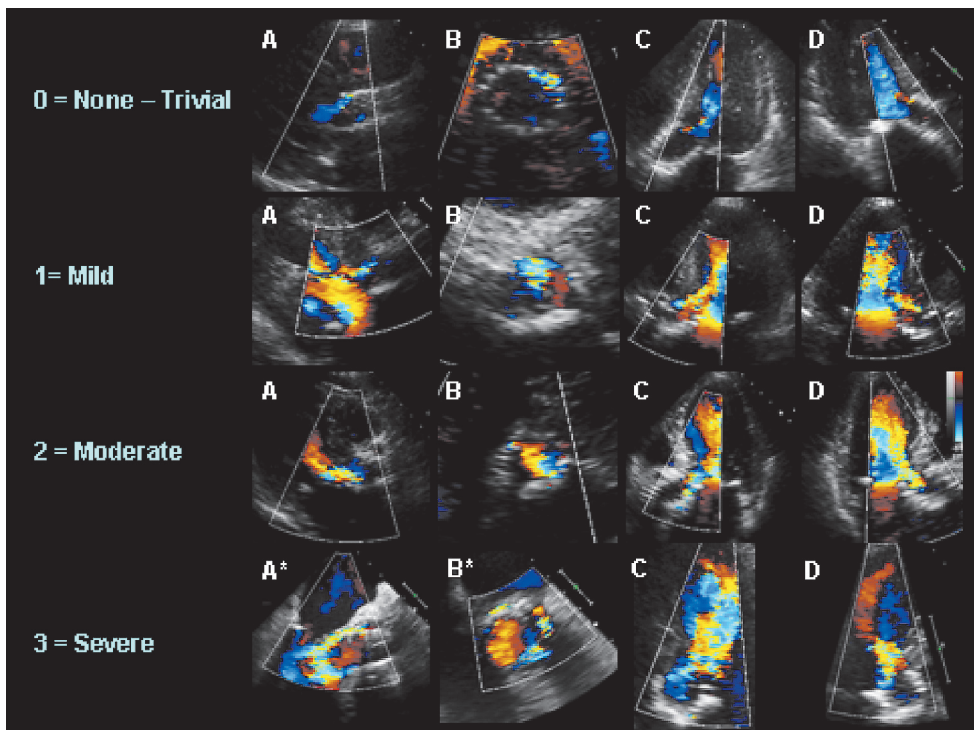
Grading of the severity of paravalvular aortic regurgitation (PAR) on transthoracic echocardiography (TTE).
